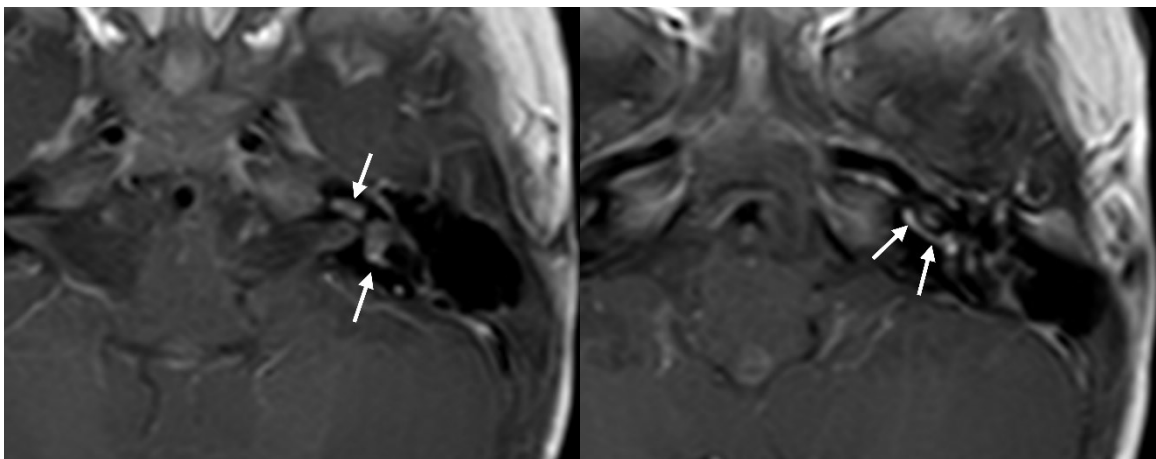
12-year-old male with left labyrinthitis. Post-contrast T1-weighted image (A, B) showed enhancement (arrows) in the left inner ear, including the cochlea and vestibule, consistent with labyrinthitis.
